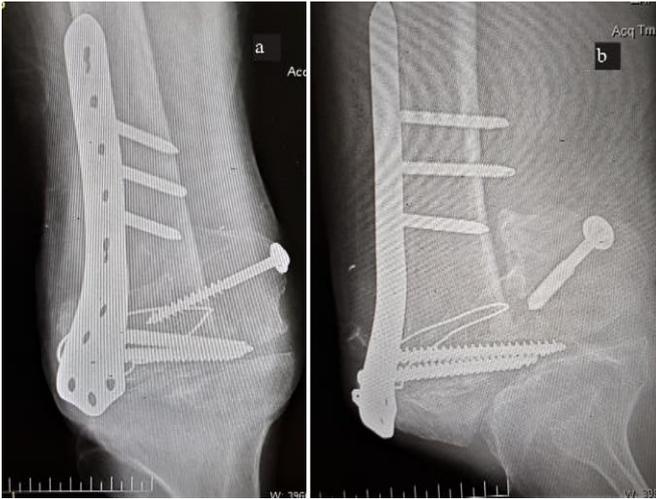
(A and B): Antero-posterior and lateral view radiograph of the right knee with nonunion and implant failure.
